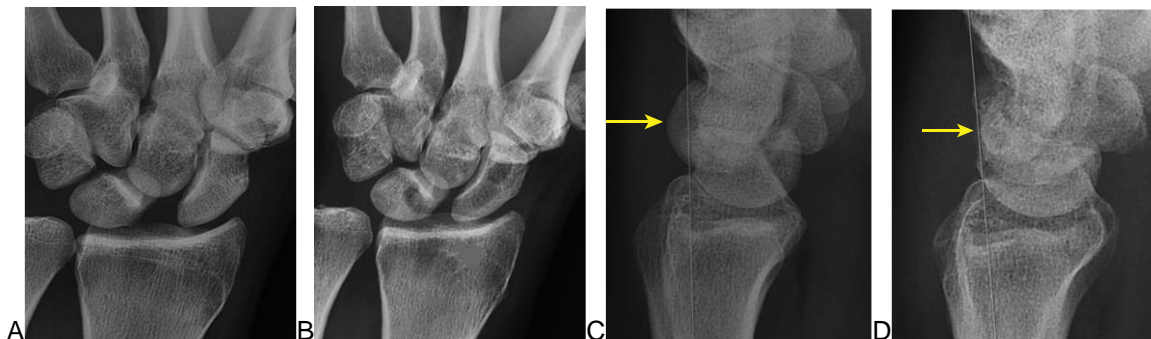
A, coronal plane radiograph showing static reducible SL lesion with SL gap >3 mm. B, postoperative radiograph in coronal plane showing SL gap reduction. C, sagittal plane radiograph showing SL lesion with Dorsal Intercalated segment Instability (DISI) and dorsal subluxation of scaphoid. D, postoperative radiograph in sagittal plane showing correction of DISI and subluxation of scaphoid.
